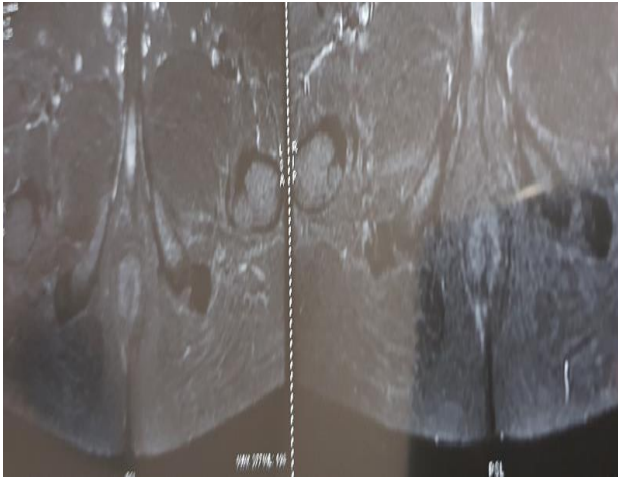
MRI T-2 phase showing low trans-sphincteric fistula.
